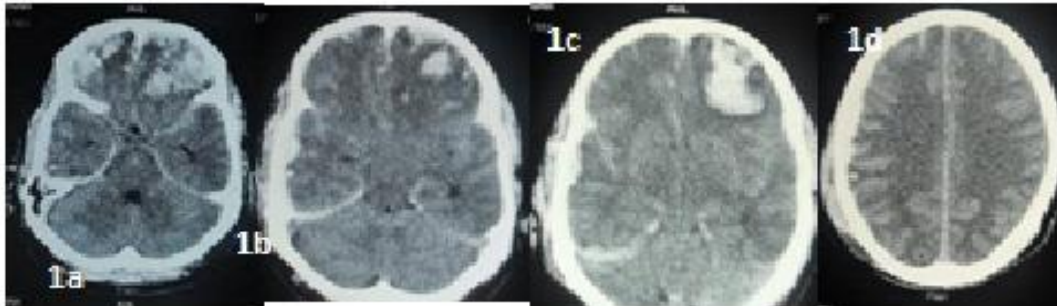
(a, b, c)- Axial CT scan of brain showing left frontal contusion, diffuse cerebral edema with obliterated ventricles and basal cisterns and right fronto-temporo-parietal subdural hematoma.
